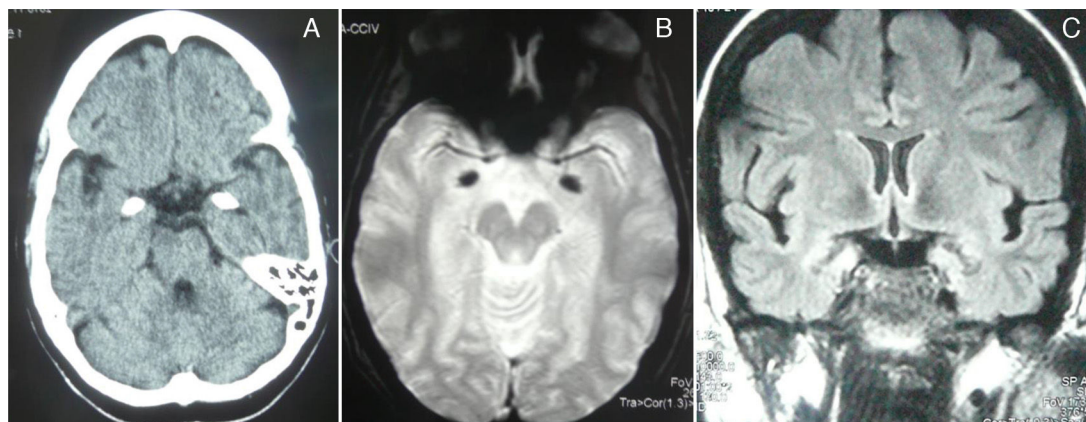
Non-contrast CT displaying bilateral symmetrical hyperdensity, axial T2*-weighted gradient-echo MRI (hypointensity), and coronal FLAIR MRI (hyperintensity) in the amygdalae and unci. Findings were compatible with calcifications.
